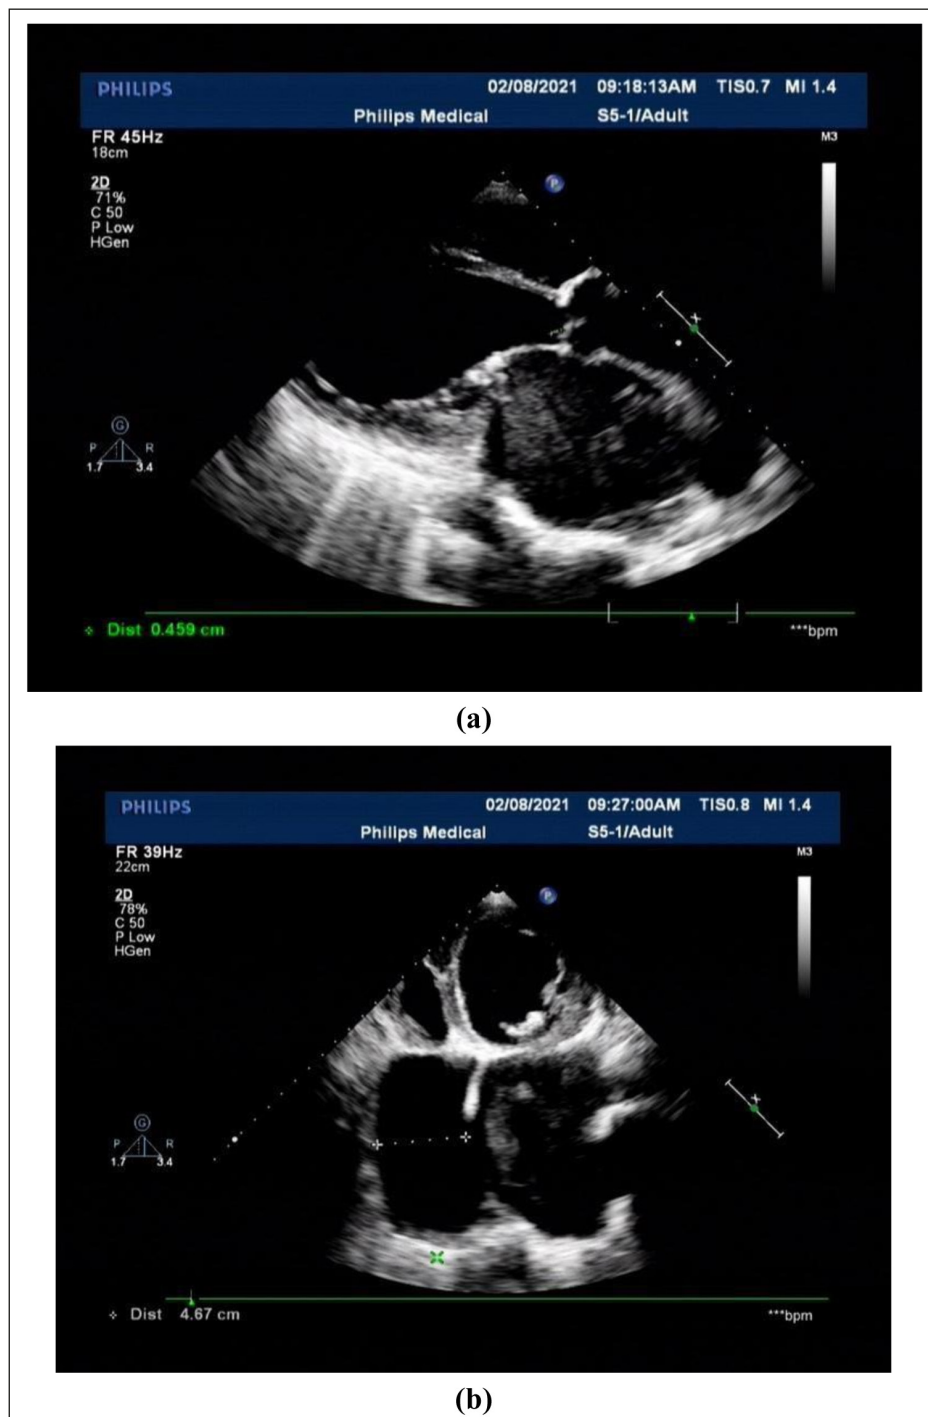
Echocardiogram of a patient with positive LAAT (a) with vertical measurement (b) with both vertical and horizontal measurement.
